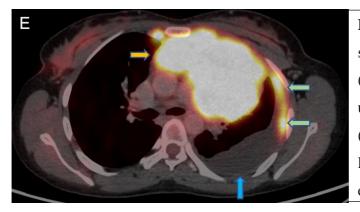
Axial PET-CT image showing large mediastinal mass (yellow arrow) with diffuse FDG uptake. FDG avid pleural deposits (green arrow) are seen along the left lateral chest wall. Left pleural effusion (blue arrow) also seen.
